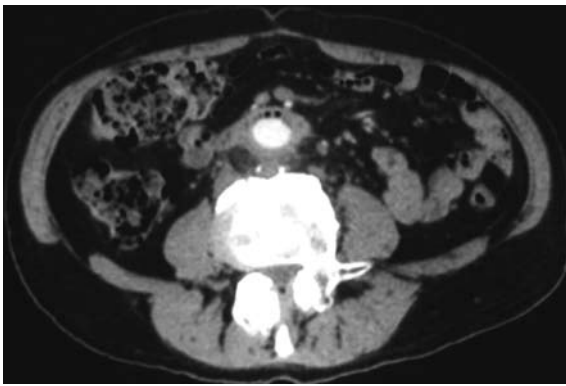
CT scan showing an area with the characteristics of inflammatory tissue including air bubbles between the duodenum and aortic-bi-femoral prosthesis adherent to the third duodenal portion.
